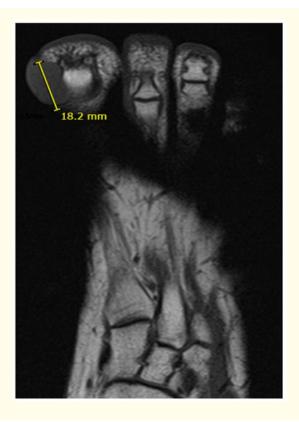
Coronal views of the lesion on MRI, T1 and T2-weighted respectively.
